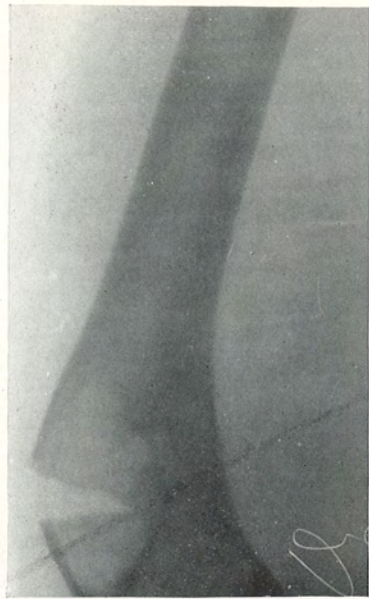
Radiograph of Case II on admission. Shows the largest of the cysts and line of spontaneous partial fracture.
